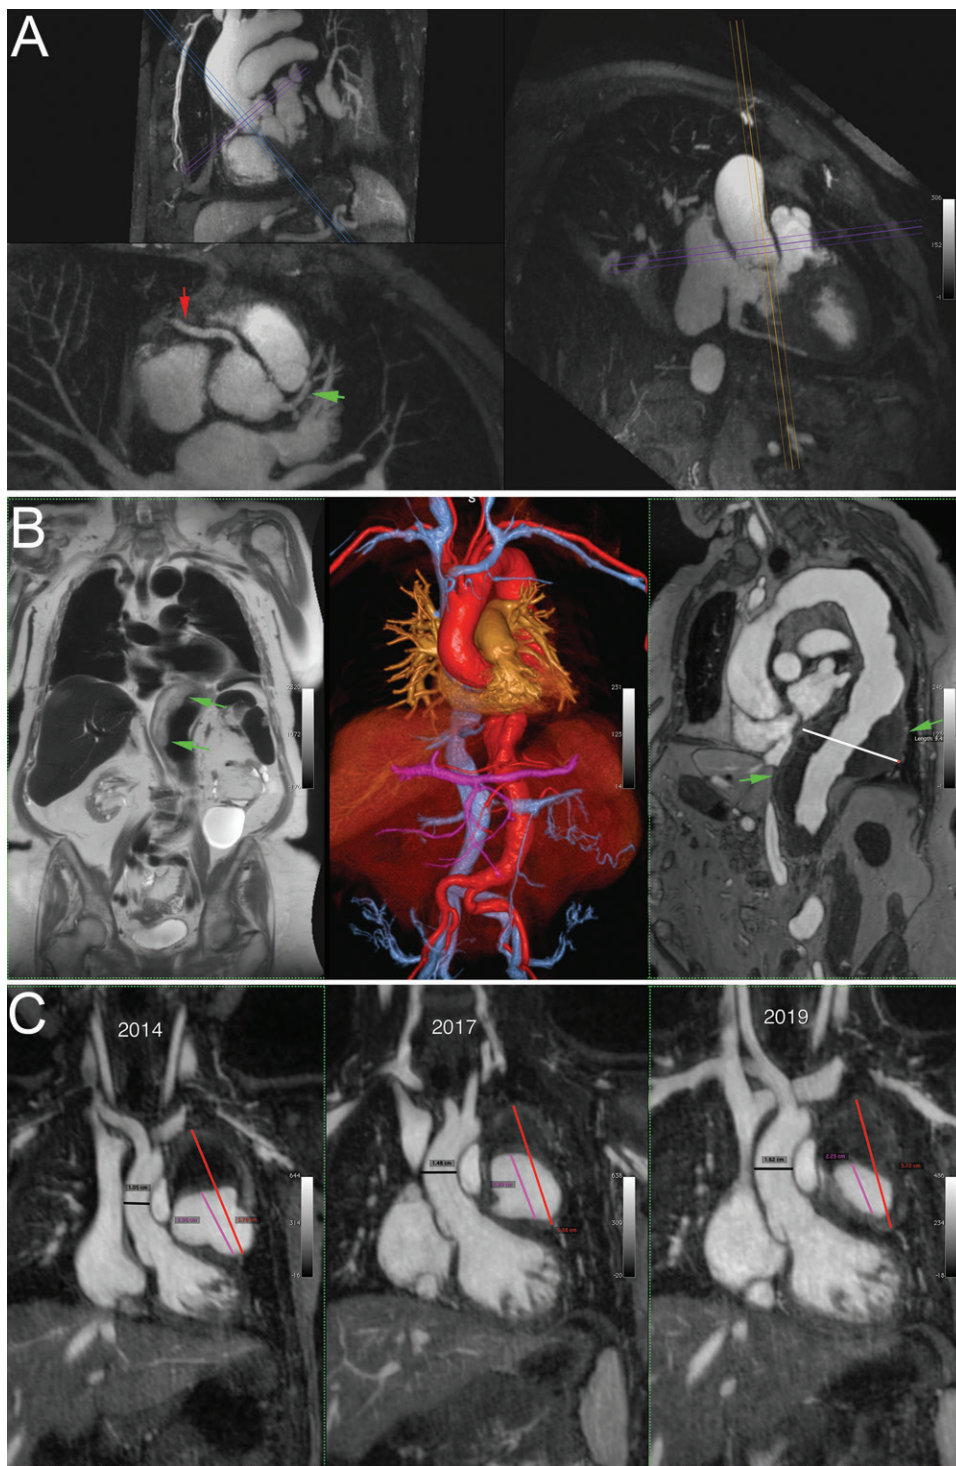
A, Coronary images in an 87-year-old male patient prior to transcatheter aortic valve replacement (maximum intensity projection showing the height of the coronary takeoff [upper panel], the ostium, and proximal segments of the right coronary artery [lower panel, red arrow] and left coronary artery [lower panel, green arrow], and an oblique view of the aortic root in relation to other vessels). B, Vascular mapping with complementary ferumoxytol-enhanced black-blood (left panel), color three-dimensional volume-rendered reconstruction (middle panel), and bright-blood (right panel) MRI techniques in an 83-year-old woman with a partially thrombosed (green arrows) 9.4-cm thoracoabdominal aneurysm. C, Sample images over a 5-year span in a girl with Kawasaki disease who was examined annually since presentation at 15 months of age. Note progressive thrombosis of the left main coronary artery aneurysm from 2014 (left panel) to 2017 (middle panel) to 2019 (right panel). The progressively narrowed vascular lumen of the aneurysm (pink line in the left, middle, and right panels) is accompanied by a relatively stable overall aneurysm size (red line in the left, middle, and right panels).
